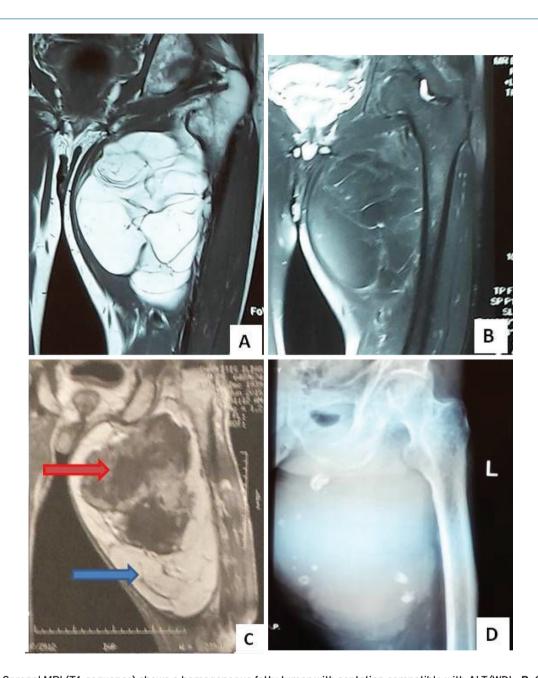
A: Coronal MRI (T1 sequence) shows a homogeneous fatty tumor with septation compatible with ALT/WDL. B: Coronal MRI (T1 with fat suppression): the whole fatty tumor except from the fibrous septa is suppressed. C: Coronal MRI (same sequence) 6 years later: the tumor has grown in size and has dedifferentiated, as depicted by the arrows: blue arrow shows the same fatty component, however red arrow shows the dedifferentiared area of the tumor, consistent with a high grade sarcoma. D: xray of the thigh showing many calicified foci within the tumor, consistent with the dedifferentiated areas. The femoral bone is not involved.
